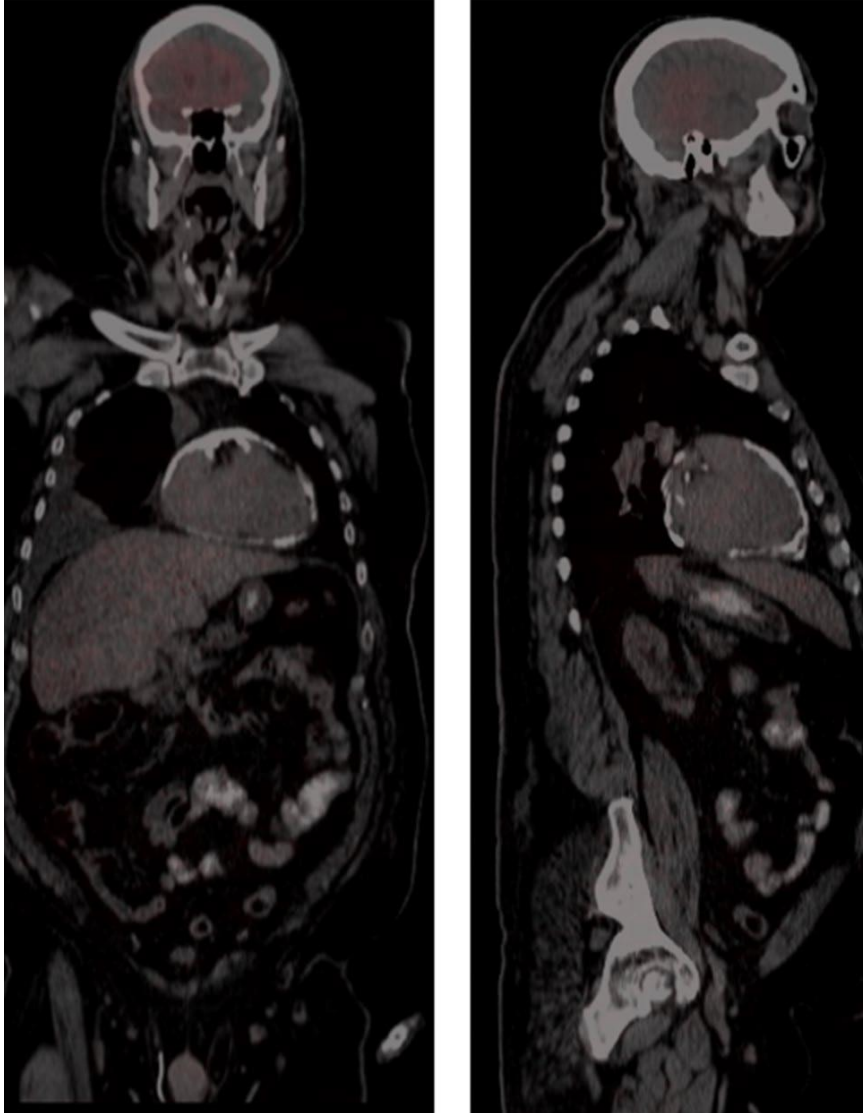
A 62-year-old male with symptoms of heart failure and right pleural effusion. Adequate assessment of cardiac function could not be performed on echocardiography due to a poor acoustic window. ^{18}F -FDG PET/CT done shows dense pericardial calcification with no associated significant metabolic activity confirming the late sequelae of a previous episode of tuberculous pericarditis. These images emphasize the utility of ^{18}F -FDG PET as a tool to differentiate between an active tuberculous pericarditis requiring anti-tuberculous medication with anti-inflammatory therapy using corticosteroid versus the sequelae of a previous infection requiring a different approach to therapy such as pericardial decortication.
